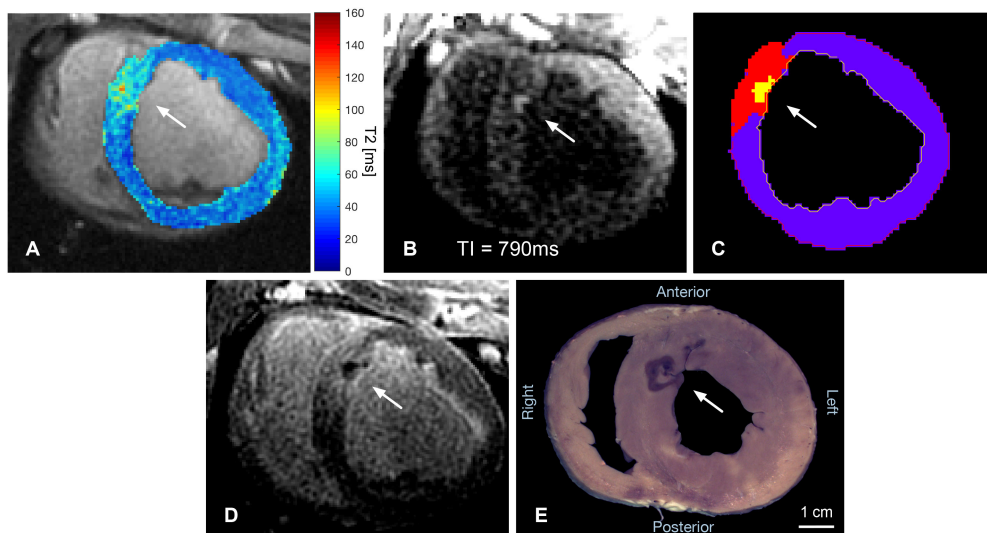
MR visualization of an RF ablation lesion on the LV septal wall in a short-axis slice - (A) Parametric T2 map showing elevated T2 associated with edema (arrow). (B) T1-weighted IR-SSFP showing hyperenhancement (short T1) at the RF lesion core (arrow). (C) Combined segmentations from (A) and (B) (purple=myocardium, red=T2-derived edema, yellow=T1-derived lesion core). (D) 3D LGE, 14 min after gadolinium injection. (E) Gross pathology slice at a location corresponding to the MRI and cut in a similar short-axis orientation.
